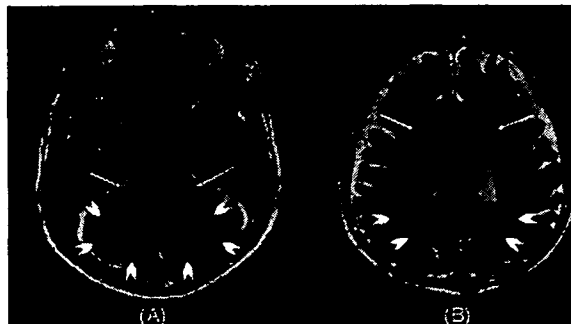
T2-weighted brain MR images (SE, TR/TE: 4080/100ms). Brain MRI showed symmetrical hyperintensity lesions in bilateral cerebellar hemispheres (arrowheads), middle cerebellar peduncles (arrows) (A), periventricular white matter (arrows) and (B), deep white matter (arrowheads).
